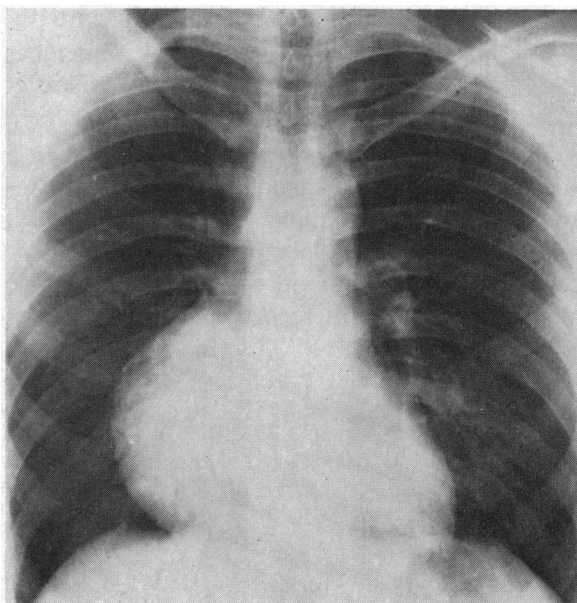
X-ray film of chest showing increased density overlying the right heart border.
